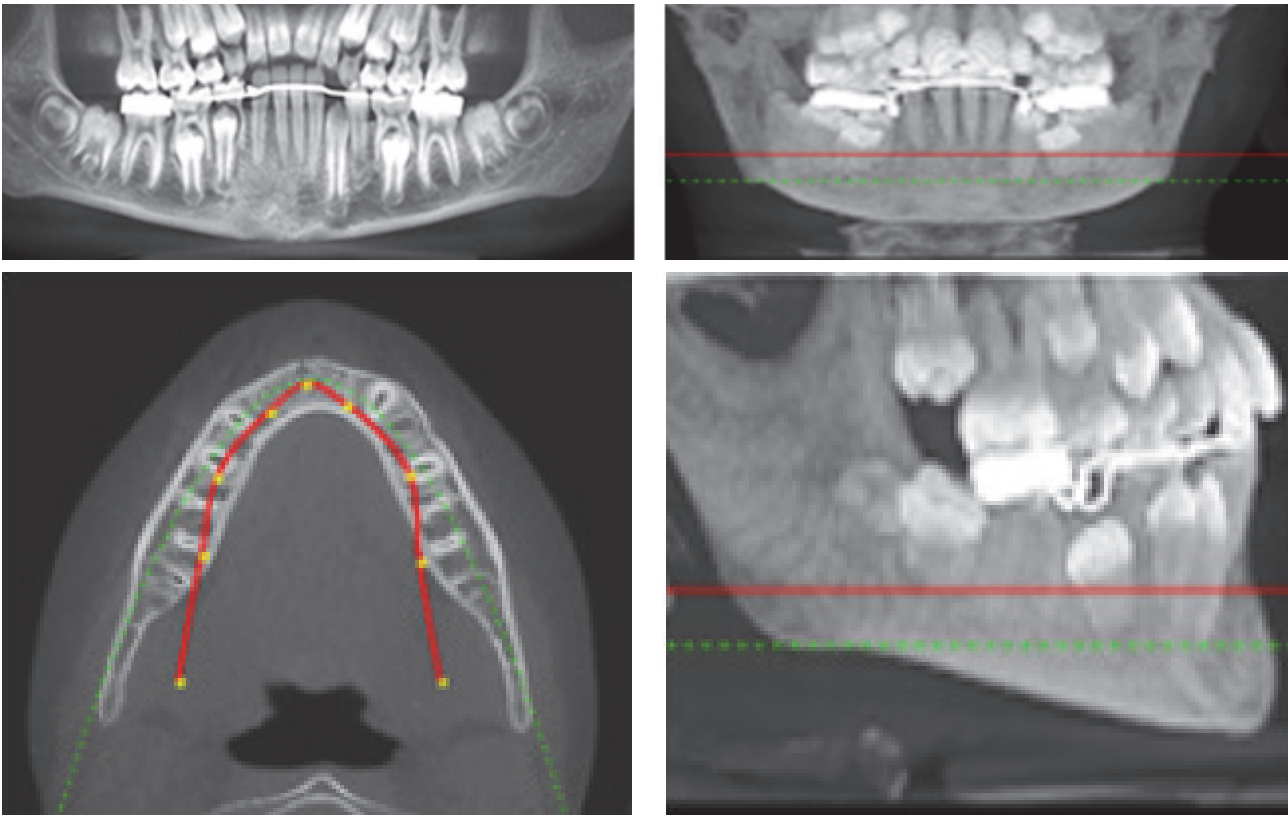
Six months post-operative CBCT.
